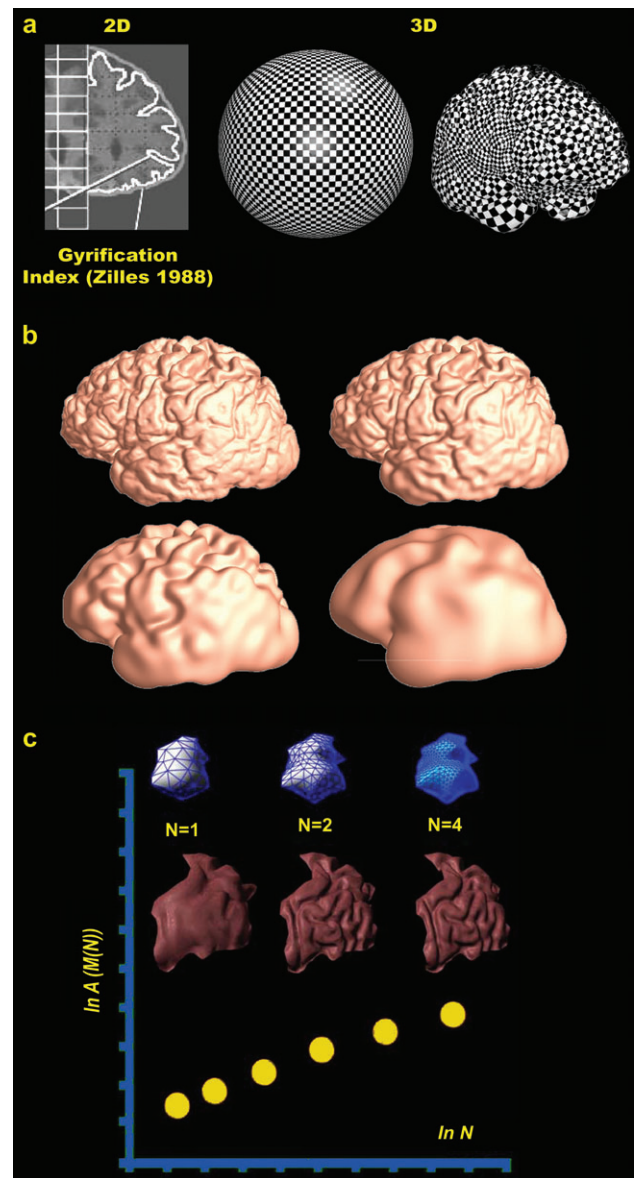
Measuring cortical complexity in three dimensions. Measuring cortical complexity in three dimensions does not depend on the orientation in which the brain is sliced and thus avoid biases associated previous 2D methods such as gyrification index (GI). (a) GI measures cortical folding based on a series of MRI sections (adapted from Zilles et al. 1988). The GI compares the boundary of the inner contour of the cortex, following sulcal crevices, with the boundary of the cortical convex hull, which is the convex curve with smallest area that encloses the cortex. The ratio of these is computed and expressed as a weighted mean across slices. Instead, our approach computes complexity from a spherical surface mesh that is deformed onto the cortex. The cortex is then mathematically regrided at successively decreasing frequencies (b), such that smoother cortices have less surface area. By plotting the observed surface area versus the cutoff spatial frequency in the surface representation, on a log-log plot (c), more complex objects have greater gradients. This plot is called a multifractal plot: the x-axis represents the log of number of nodes in the surface grid (here denoted by $\ln N$), and the y-axis measures the log of the surface area of the resulting mesh [here denoted by $\ln A(M(N))$, where A is the area function and $M(N)$ is the surface mesh with N nodes]. For nonflat surfaces, this plot has a positive slope because the surface area increases as more nodes are included in the mesh. The slope of this plot is added to 2 to get the fractal dimension of the surface (Thompson et al. 1996) (3D figure in b and c were adapted from Gu et al. 2003). Adding the gradient of the multifractal plot to 2 is a convention used when computing fractal dimensions for surfaces. It ensures that the computed fractal dimension of a flat 2D plane agrees with its Euclidean dimension, which is 2, because the surface is 2D (for details, see Methods).
